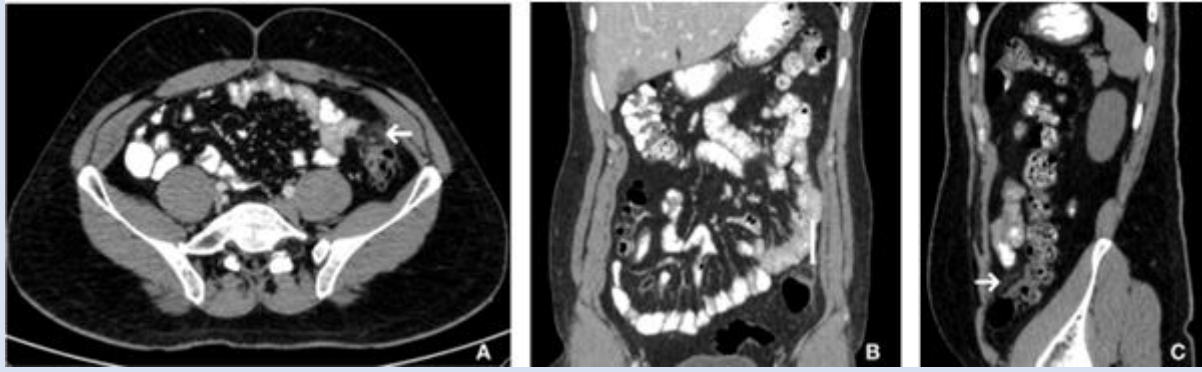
(A, B and C) - Axial (6A), Coronal (6B) and Sagittal (6C) sections of CT abdomen with contrast show small oval area inflammatory fat stranding surrounded by a soft tissue ring anterior to the sigmoid colon represented by arrows.
